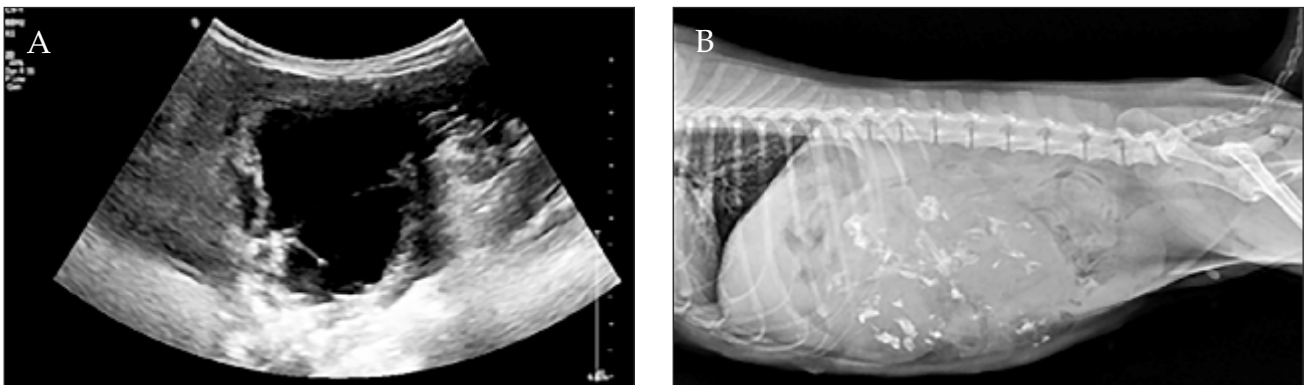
(A) Ultrasonographic image of ovarian tumour with presence of cystic lesions inside it; (B) Radiograph shows areas of calcification present inside the ovarian mass most likely to be ovarian teratoma.
